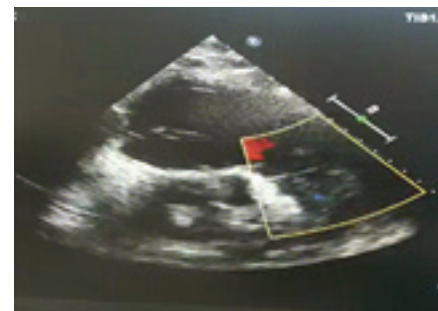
echocardiography at the time of admission (August 2023). Regurgitation on the pulmonary artery valve
